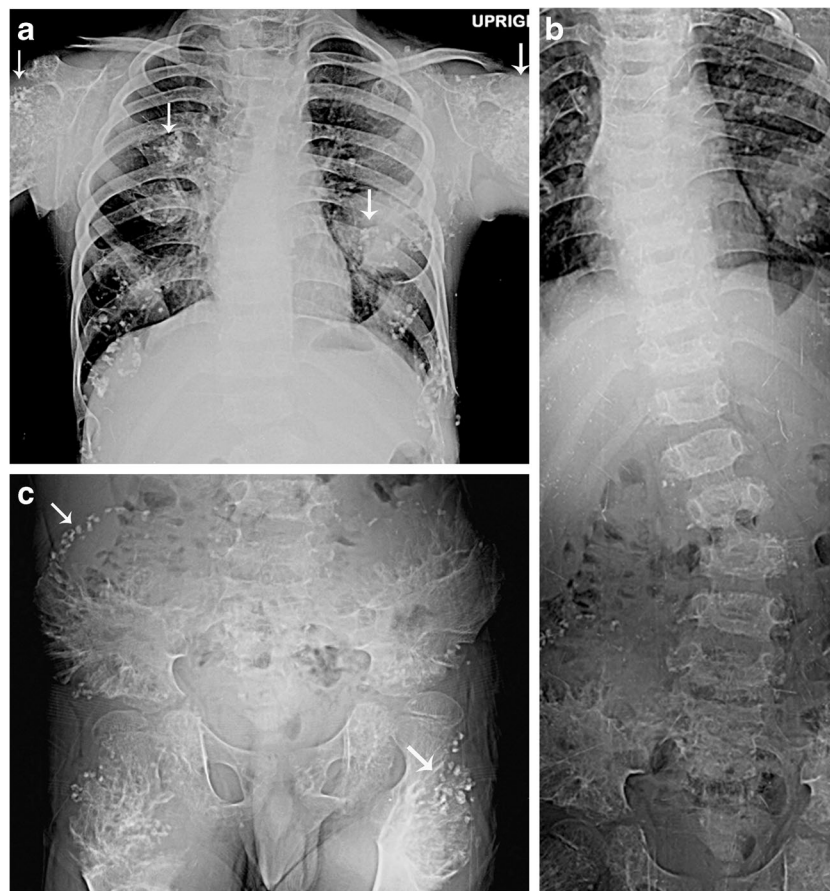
Plain radiographs of the patient at 7 years of age. a The posteroanterior chest radiograph revealed bulbous, expansive costovertebral junctions at several levels together with stippled calcification in the area of noncalcified costal cartilages. Bilateral proximal humeri also showed splaying columns of lucencies and streaks through the metaphyses associated with punctate calcifications in the area of deficient ossification. b-c The radiographs of the spine and pelvis showed levococonvex scoliosis of the thoracolumbar region
